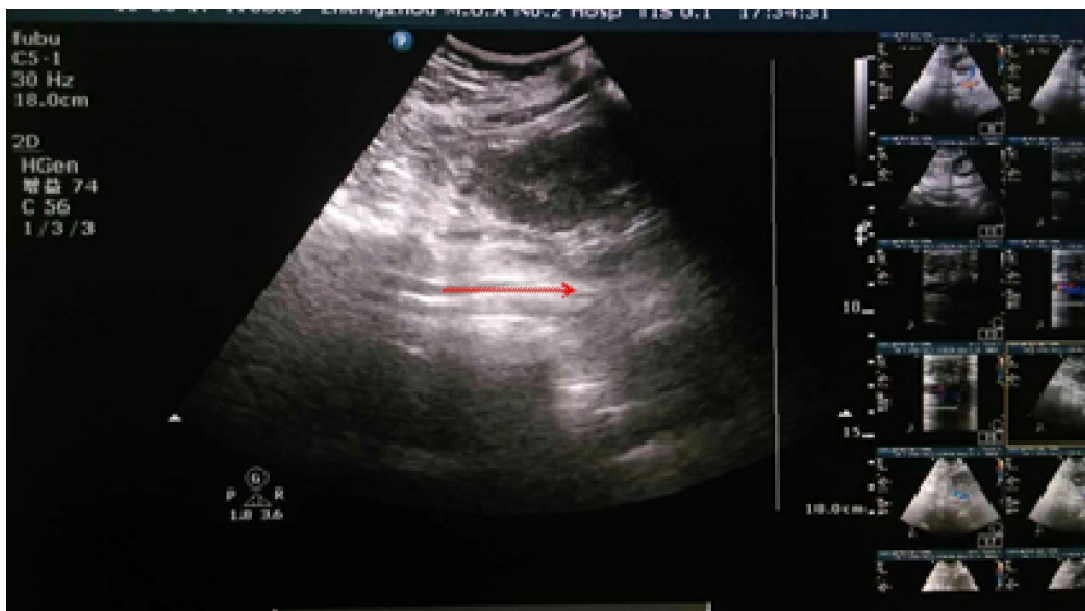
ultrasound guided balloon positioning. The red arrow is the balloon, which located between the bifurcation of the abdominal aorta and renal artery opening.
